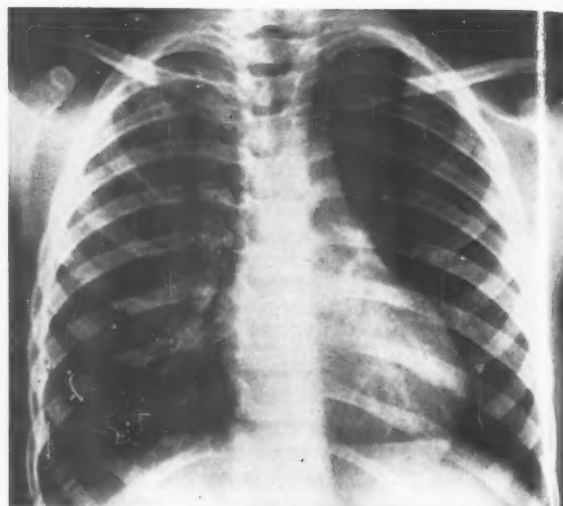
S.R.: Normal radiograph four years later: no calcifications.
